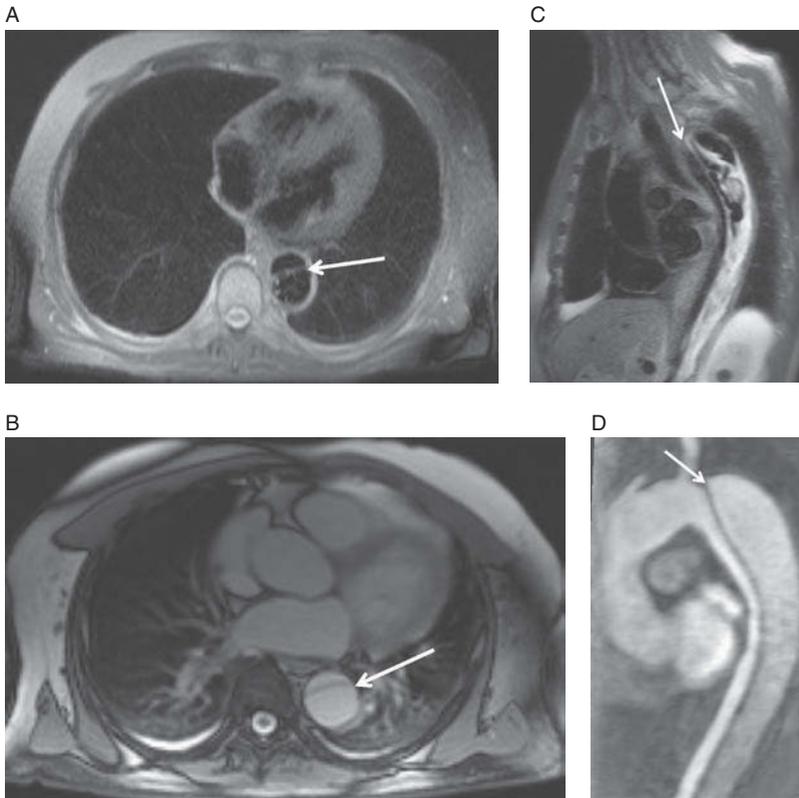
Type B aortic dissection. Axial dark-blood image (A) and cervical bright-blood image (B) demonstrate intimal flap within descending thoracic aorta indicative of aortic dissection (arrows). Note the dark true lumen and bright false lumen in sagittal dark-blood image C (arrow). This is due to slow flow within the false lumen. The flap and slow flow within the false lumen are also nicely shown in sagittal T1-weighted gadolinium-enhanced image (D) where the false lumen is not as bright as the true lumen.
